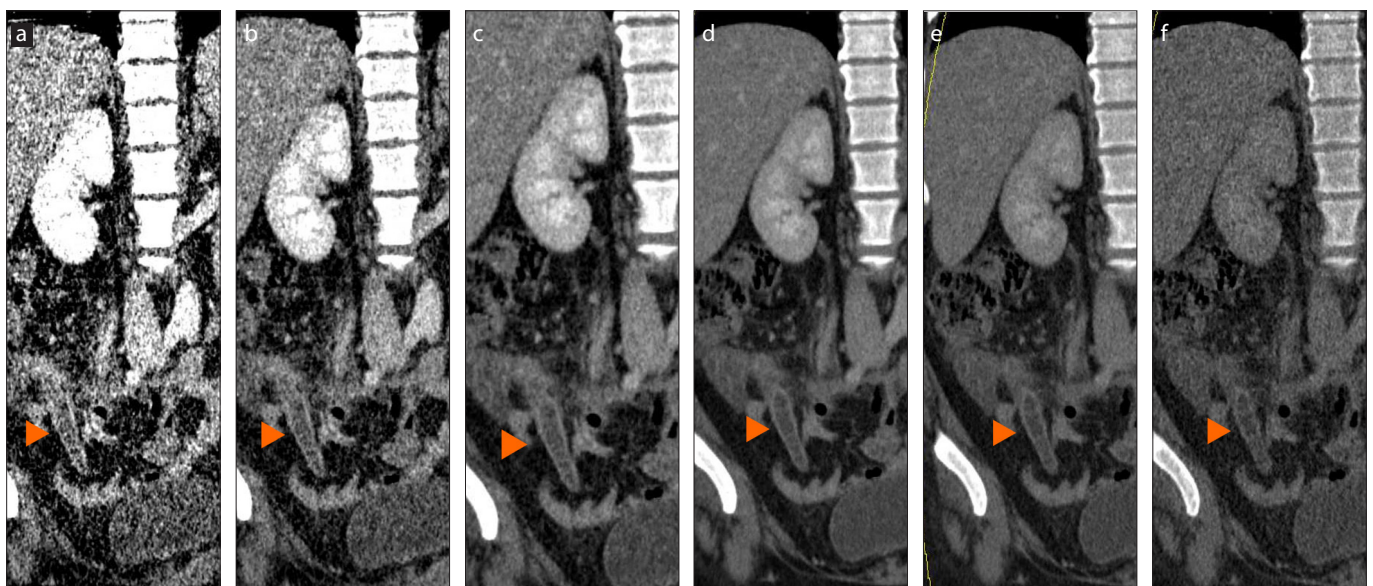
a–f. Virtual monoenergetic images can be reconstructed at different energy levels using the wide-range X-ray energy levels in DECT. Obvious higher noise rates at lower energy levels are apparent, with higher contrast enhancement (arrowheads). Appendiceal inflammation is best appreciated at energy levels of 60–80 keV: (a) 40 keV; (b) 50 keV; (c) 60 keV; (d) 70 keV; (e) 80 keV; (f) 90 keV images.
